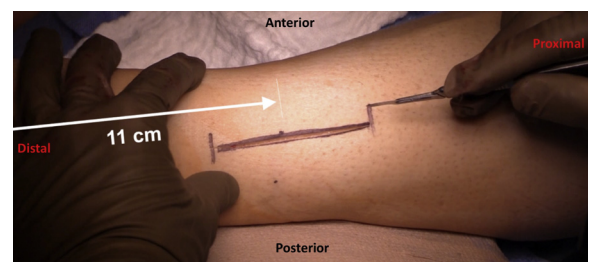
Superficial anatomic images demonstrate our preferred lateral (A) and medial (B) incision locations for 4-compartment fasciotomy in the setting of chronic exertional compartment syndrome. Representative axial cut magnetic resonance images (C, D, E) indicate the locations of critical neurovascular structures and fasciotomy locations (red asterisk) at each level. The distal lateral incision (A) is centered over the intermuscular septum 11 cm proximal to the tip of the lateral malleolus to facilitate direct visualization of the superficial peroneal nerve at its exit from the crural fascia. Identification, mobilization, and control of the nerve at this location allows performance of a controlled anterior and lateral compartment fasciotomy in the distal two-thirds of the leg (red asterisks: D, E). The proximal lateral incision (A) is localized over the posteroinferior edge of Gerdy safe zone (blue circle: an approximately 45-mm-radius circle centered on Gerdy tubercle) where the peroneal nerve and its major branches course along the posterior and inferior circumference (C). The most proximal portion of the anterior and lateral compartment fasciotomies can be completed through this incision while protecting the nerve. The medial incision is centered just off the medial tibial border overlying the saphenous nerve and vein (B, D). The posterior tibial neurovascular bundle must be visualized and protected during deep posterior compartment fasciotomy (D). Blue asterisks denote locations of skin incisions.
